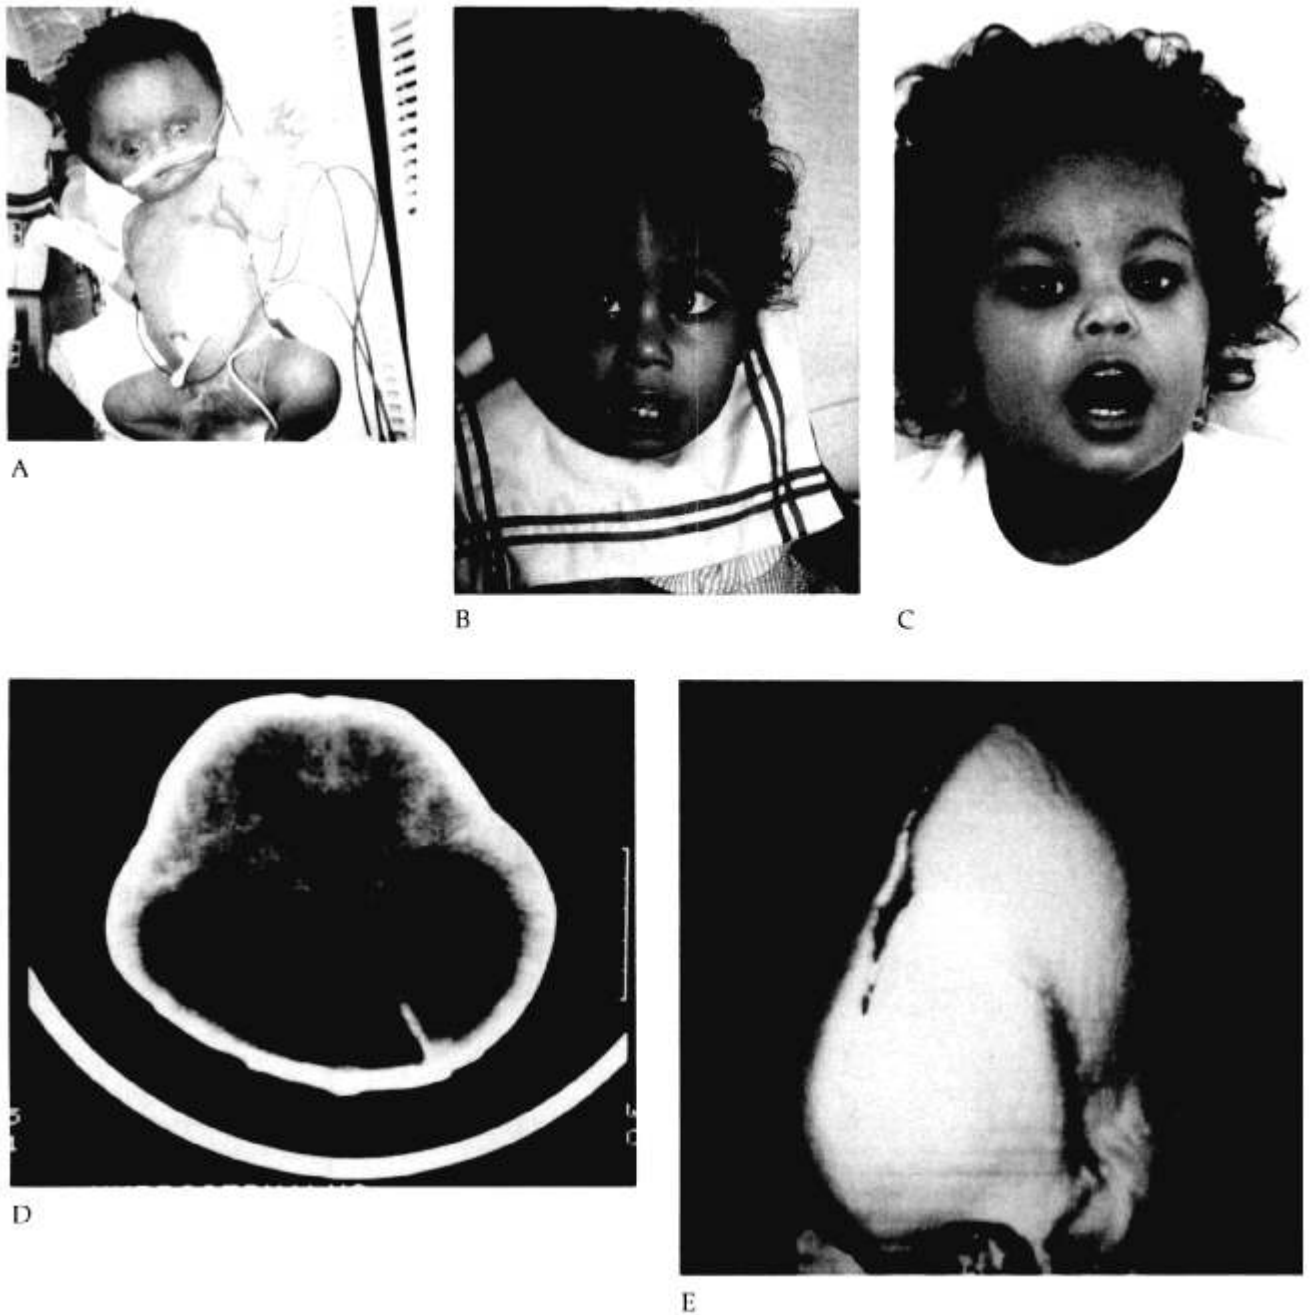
This young infant was born with massive congenital hydrocephalus requiring emergency low-pressure ventricular-peritoneal (V-P) shunt placement shortly after birth (A). A computed tomographic (CT) scan performed at 1 day of age (D) reveals the greatly enlarged ventricles. Placement of the shunt improved the hydrocephaly; however, the collapse of the cranium resulted in the cranial bones overlying each at the site of the major sutures. The skull remained in this configuration; secondary craniosynostosis of multiple sutures developed by 18 months (B, E). Three-dimensional CT scans confirmed these findings and also revealed the unusual morphology of the cranium. Correction required total upper cranial vault expansion and replacement of the V-P shunt with a higher pressure valve. Photographs taken 6 months postoperatively revealed a more satisfactory shape and appearance of the entire craniofacial skeleton (C).
